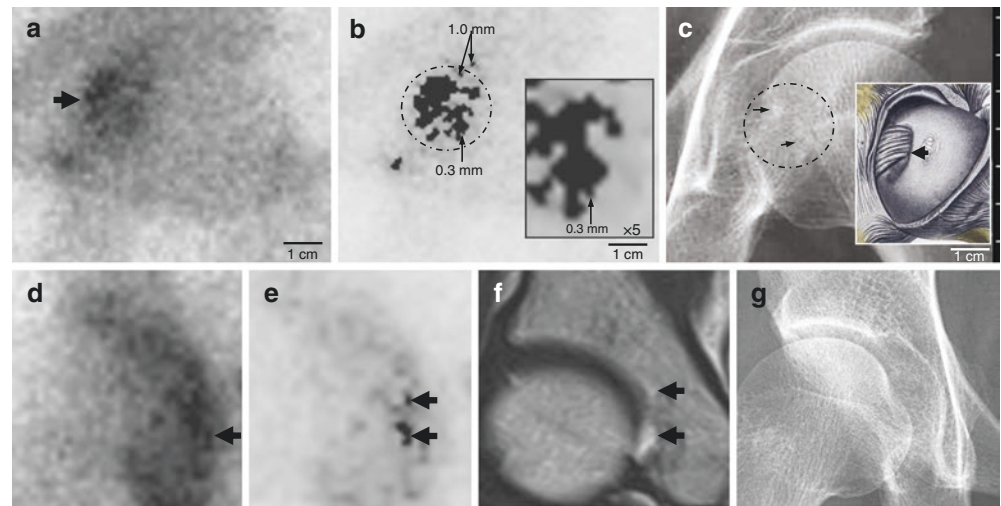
Pain in the left hip joint incited by motor vehicle accident in a 32-year-old female. (a) Naïve anterior pinhole scan shows blurry tracer uptake in the fovea (arrow). (b) Gamma correction view shows irregular tracer uptake (circle). Inset shows the smallest one measures 0.3 mm in size. (c) Radiograph shows deranged trabeculae with calcification (circle and arrows). Inset shows anatomy of the fovea and ligament (arrow) (Adopted from Clement's Anatomy. Urban & Schwarzenberg, München, 1981). (d) Naïve anterior pinhole scan of the right acetabulum shows diffuse increased tracer uptake in the acetabular fossa (arrow). (e) Gamma correction view shows the washout of blurry uptake highlighting two small fractures at the acetabular terminal of the teres ligament (arrows). (f) Coronal T2-weighted (6120/96) MR image shows two mottled areas of bright signal intensity in the small fractures of acetabular insertion site (arrows). (g) Radiograph is negative
